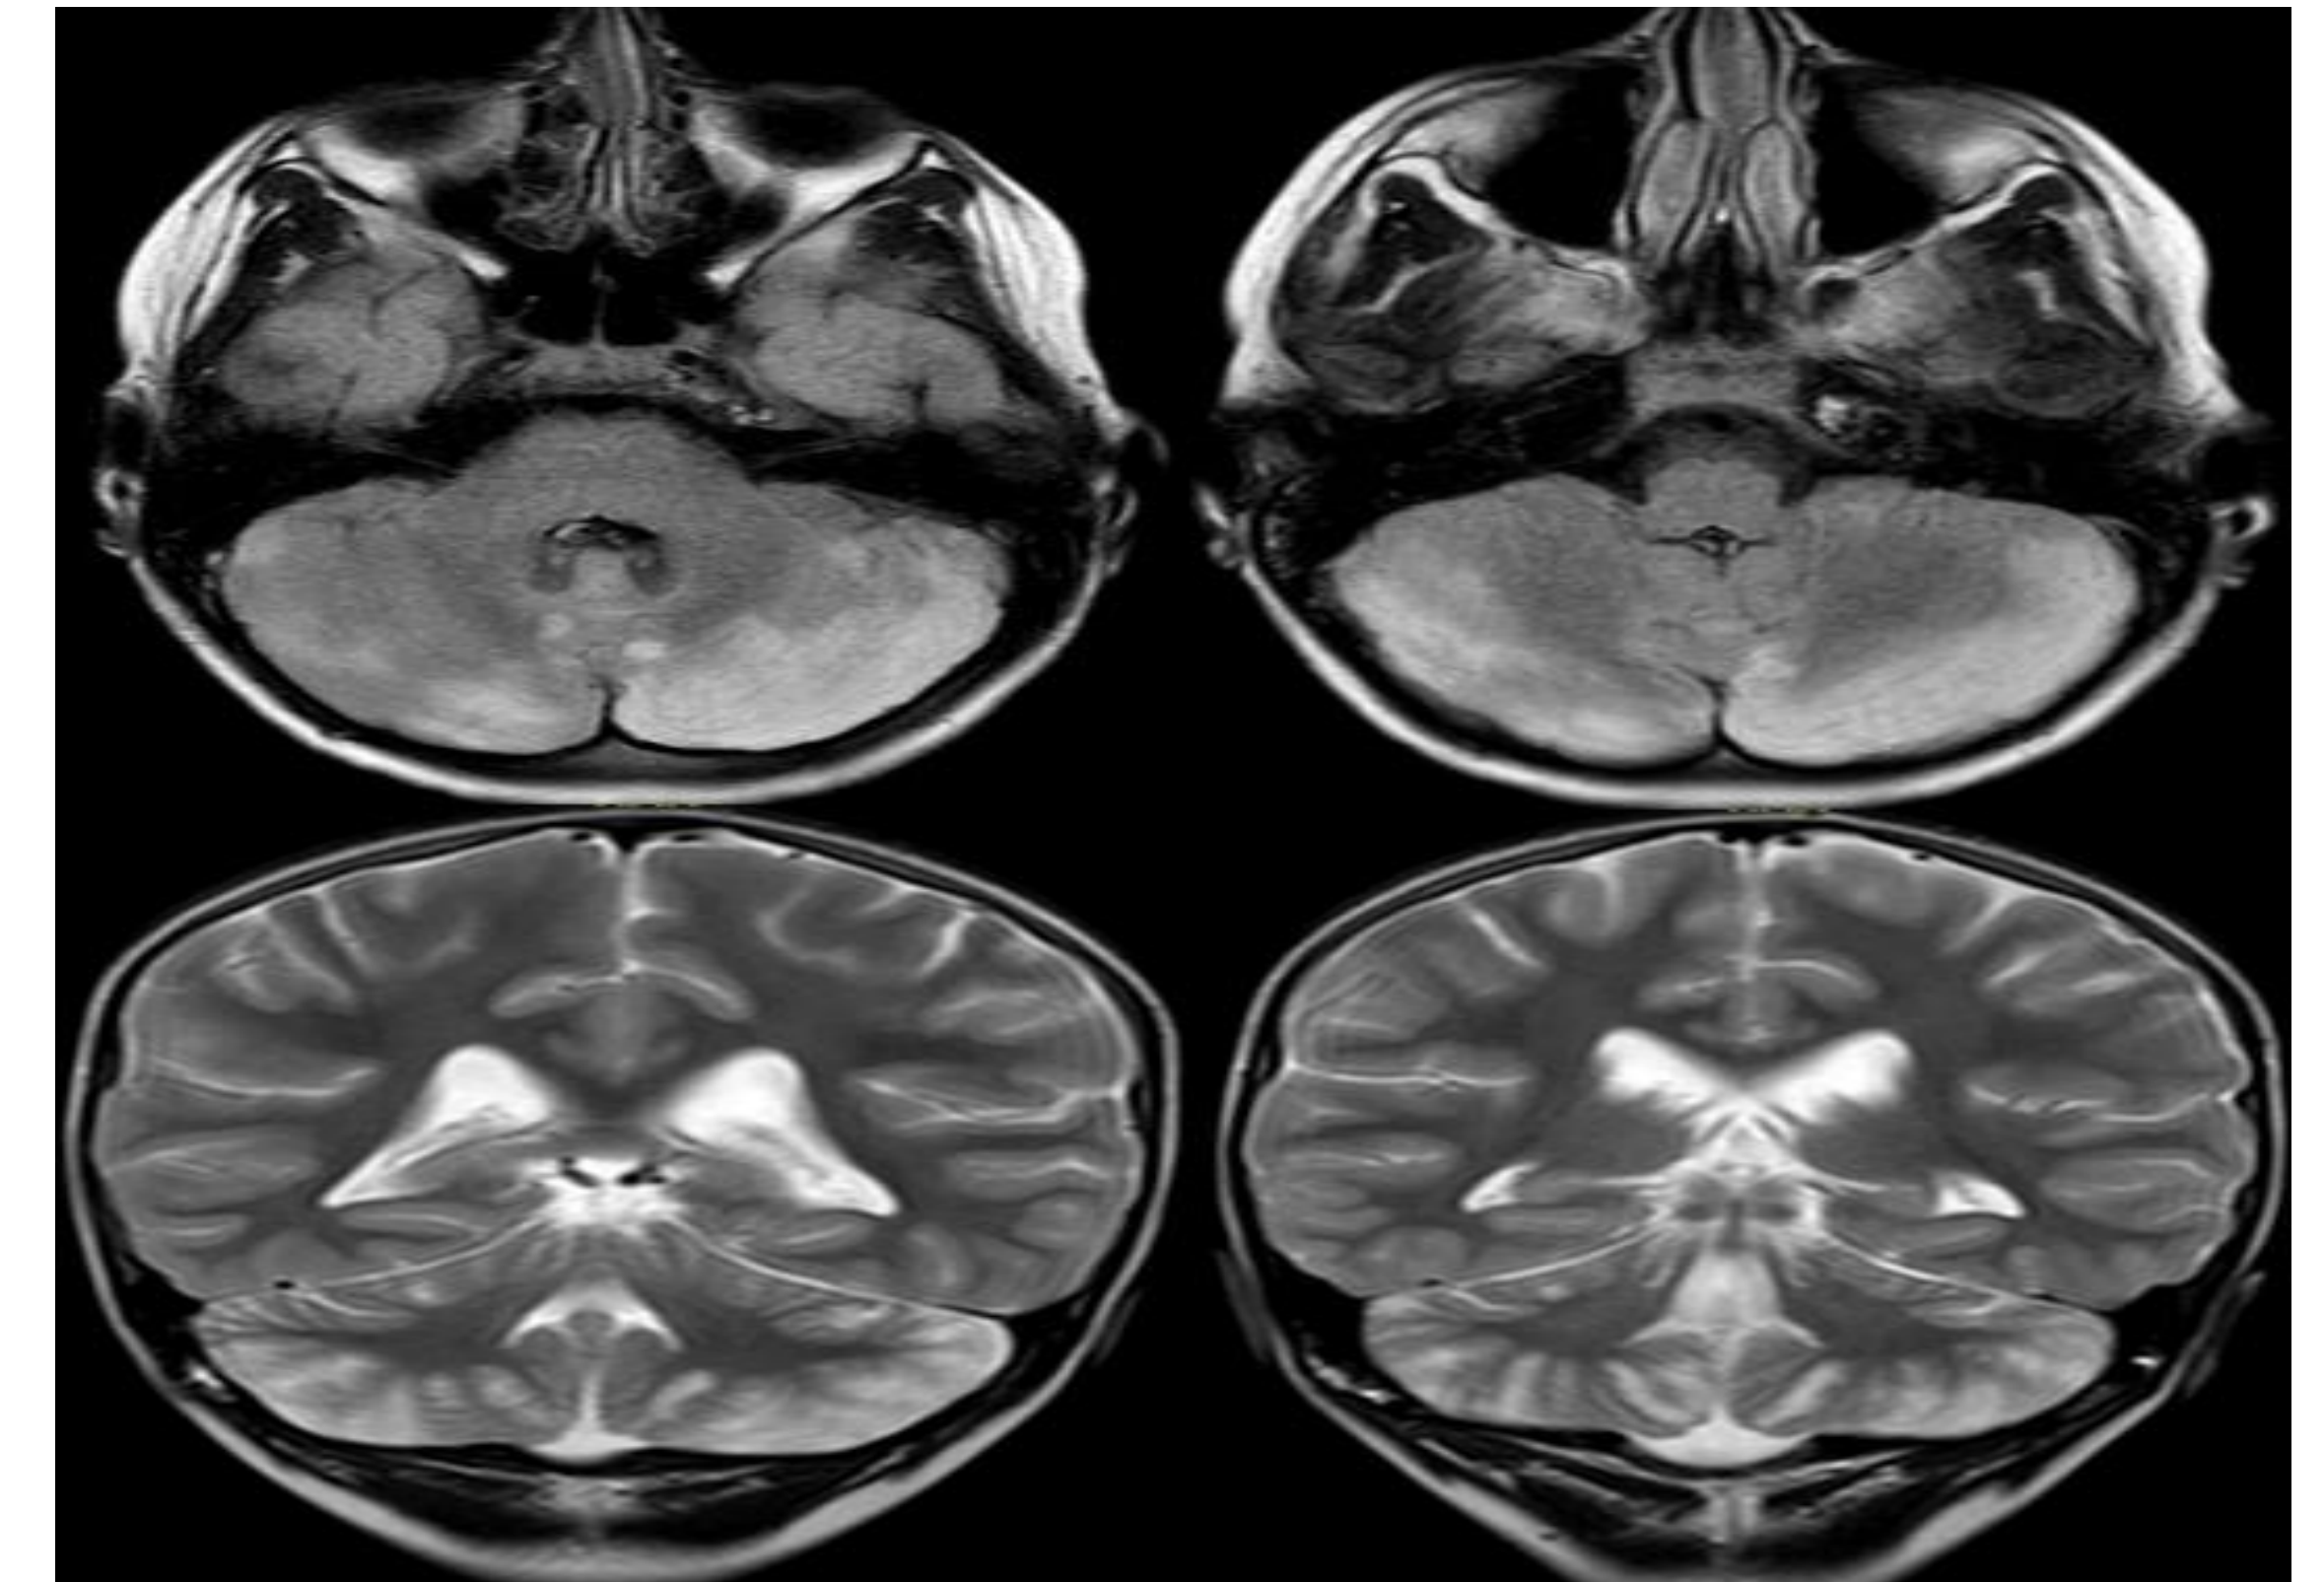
MRI findings of the patient
